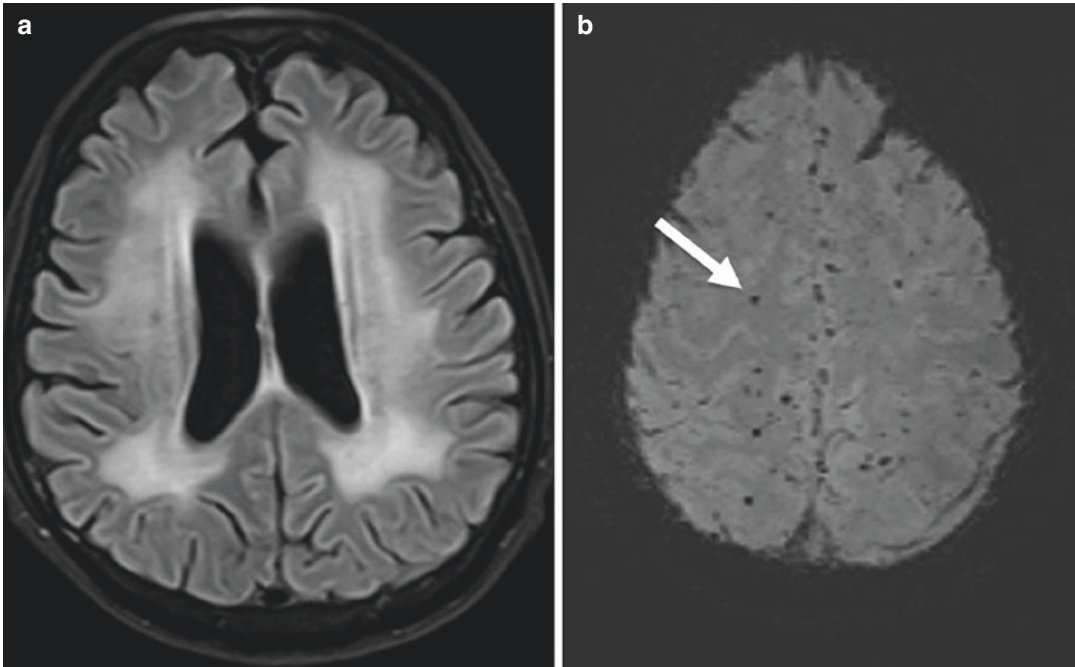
Delayed diffuse white matter injury following radiation therapy. (a) T2 FLAIR image demonstrates confluent white matter hyperintense abnormality without
